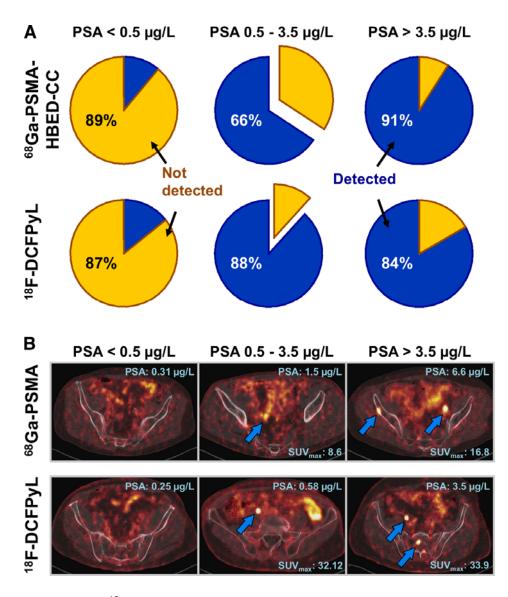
¹⁸F-DCFPyL displays enhanced sensitivity for localization of relapsed tumors after prostatectomy at limited stage. (A) Prostatectomy patients with BCR were examined with ⁶⁸Ga-PSMA-HBED-CC (top) or ¹⁸F-DCFPyL (bottom). Pie charts display the fractions of PET-positive (blue) and PET-negative (orange) patients with PSA <0.5µg/L (left), >3.5µg/L (right) or 0.5-3.5µg/L (middle). (B) Representative PSMA-PET/CT images (fusion ratio 1:1), acquired with ⁶⁸Ga-PSMA-HBED-CC (top) or ¹⁸F-DCFPyL (bottom). PSA level and SUV_{max} over the PSMA-positive lesion (blue arrows) are annotated for each scan.
